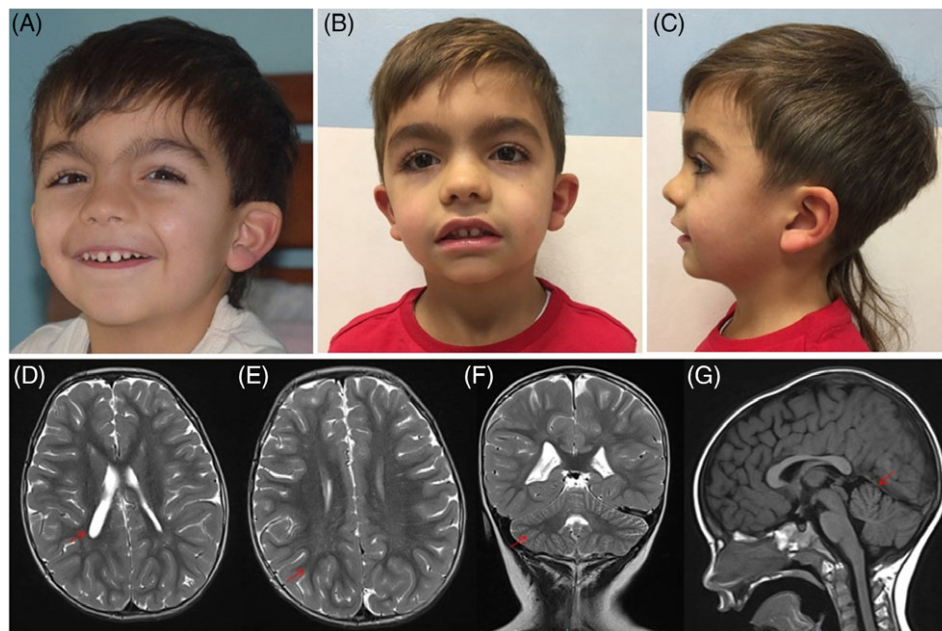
Clinical features of the patient with the novel de novo c.631G>A change in PACS2. Patient at age 5 years (A) and at 7 years and 6 months (B,C). Facial dysmorphisms, including synophrys, highly arched and sparse broad eyebrows, long eyelashes, low-set and posteriorly rotated ears with uplifted lobe, broad nasal tip, smooth philtrum, thin and everted upper lip vermillion, downturned corners of the mouth, widely spaced teeth, chin with horizontal crease. Brain MRI at 3 years and 10 months (D-G). Abnormal cerebellar foliation pattern along the basal and posterior portions of the right cerebellum hemisphere (F-G), a quantitative reduction of the white matter of the parietal regions (E). Lateral ventricular asymmetry is evident, with the right ventricle larger than the left (D) [Colour figure can be viewed at wileyonlinelibrary.com]
